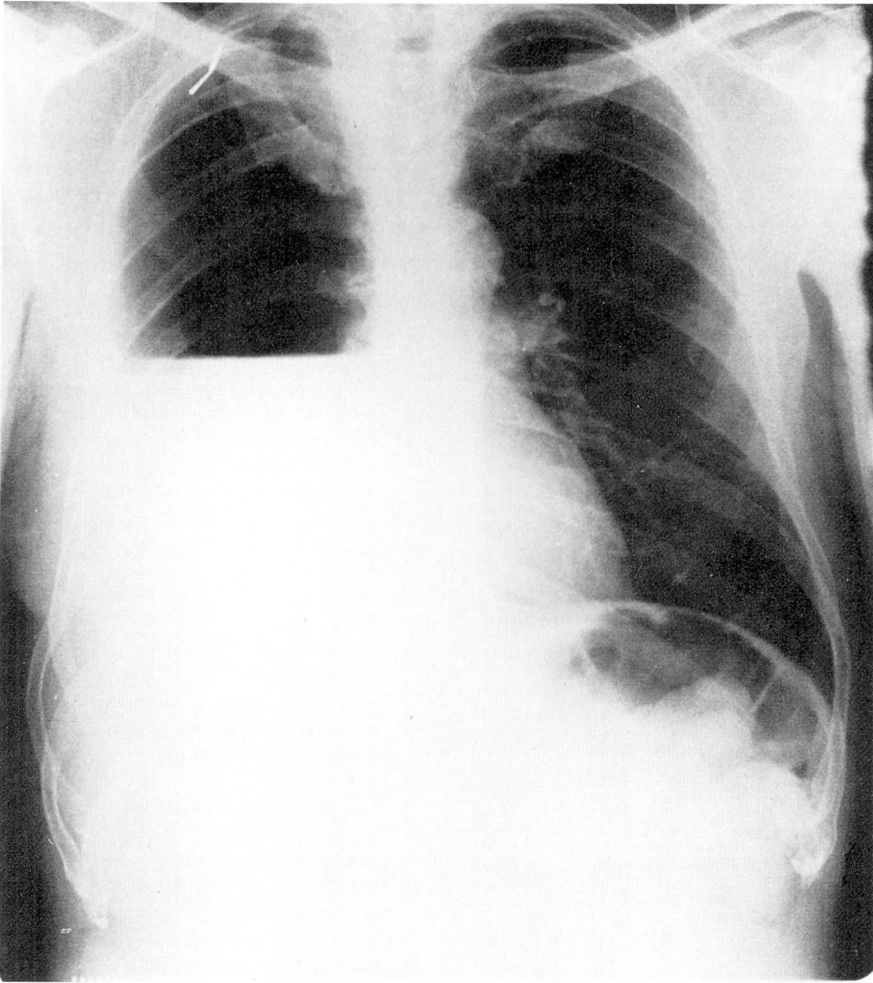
The admission posteroanterior chest roentgenogram.
